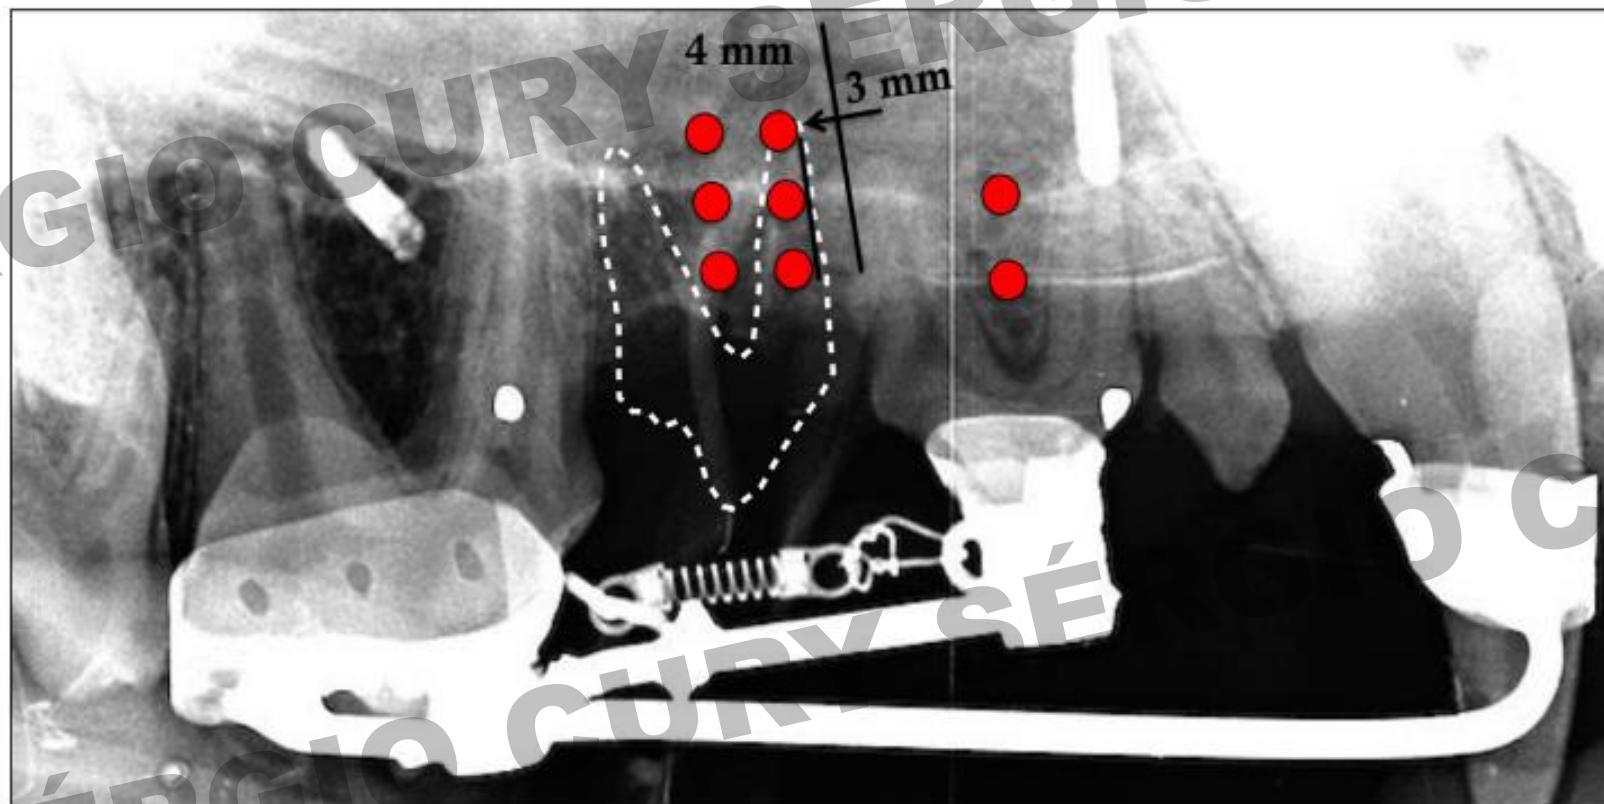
Radiograph showing the approximate locations of the 6 MOPs placed 3-7 mm from tooth root and 2 MOPs placed in the furcation. Red dots represent 1.5-mm-diameter \times 7-mm-deep MOPs. Extracted tooth outlined.
